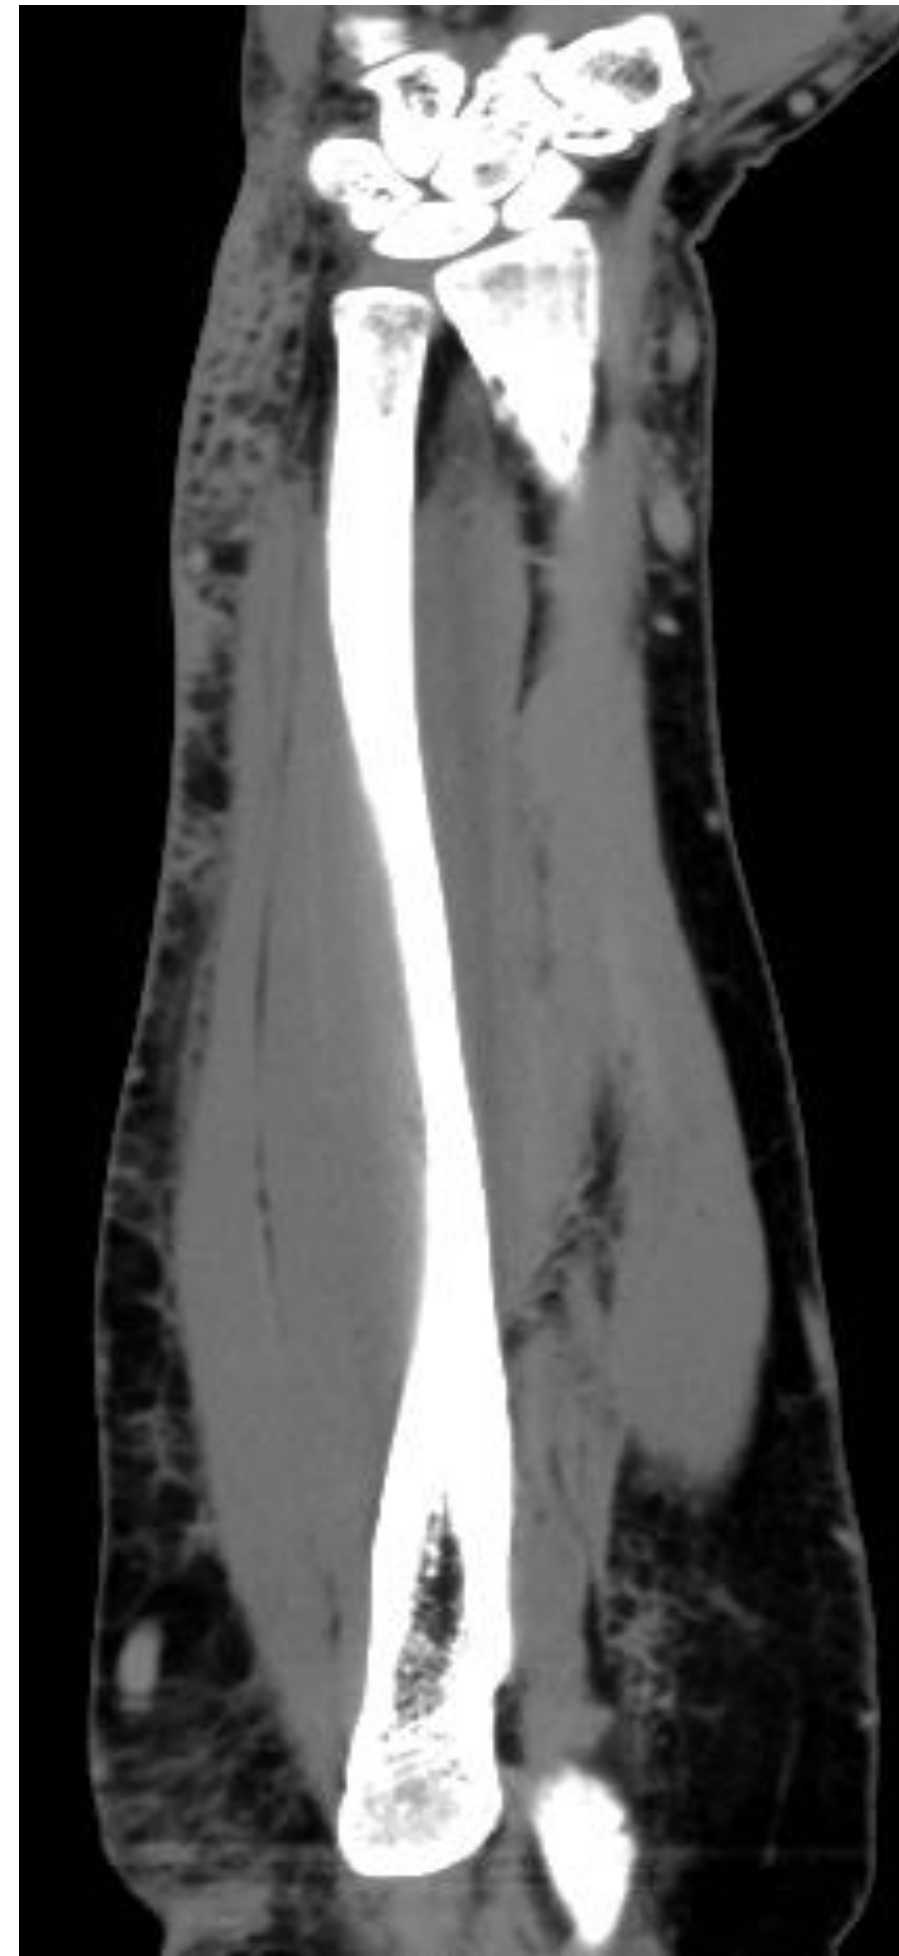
CT of the forearm revealing subcutaneous edema and inflammation.
